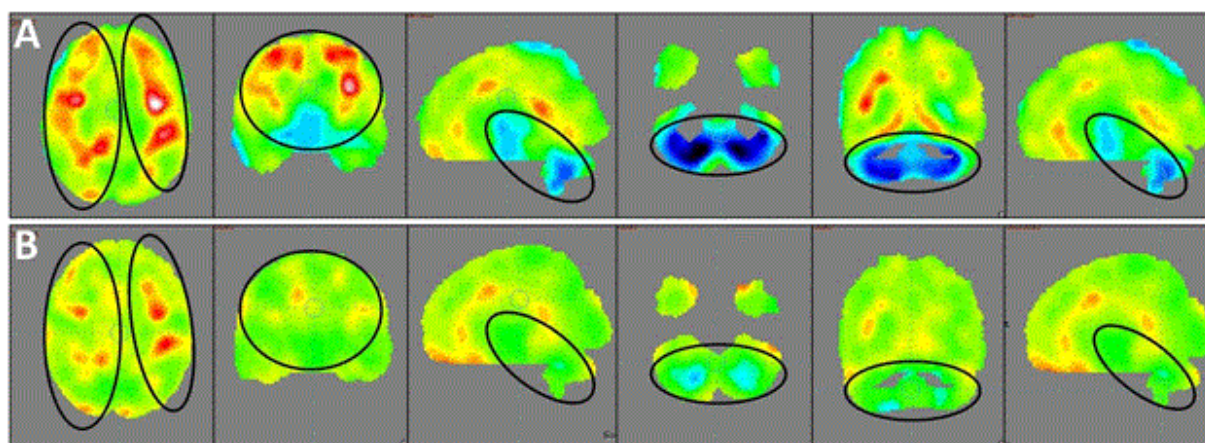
(A) PET - CT scans of the patient carried out pre - intervention. (B) Post - intervention PET - CT scans of the patient carried out after 6 months. Previously hypometabolic (hypofunctioning) brains areas depicted as blue areas show improved metabolism post - intervention, represented by green areas. Red areas representing hypermetabolism (hyperfunctioning) have improved to more normalized green areas post - intervention. The images reveal a balancing effect on overall brain metabolism
